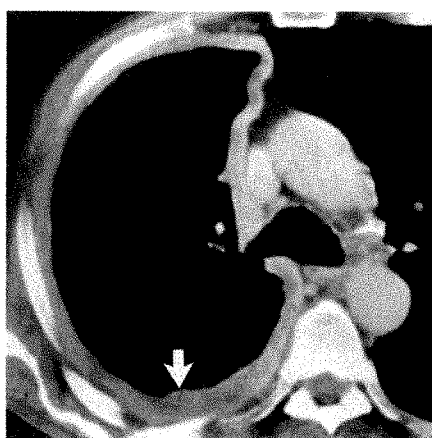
CT scans at level of tracheal carina in a 59-year-old man with desmoplastic mesothelioma.
